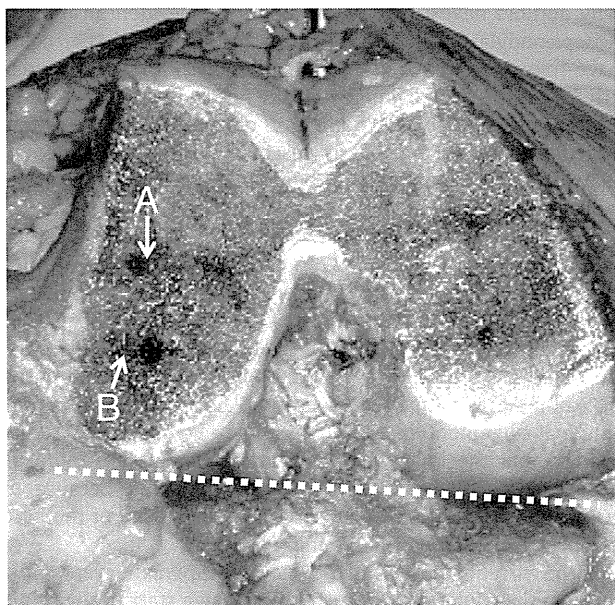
Axial cross-section of the right distal femur. A: a blue line “p-CTA $+2^\circ$ ” externally rotated from PCA. B: a blue line “p-CTA -2° ” externally rotated from the PCA. PCA is the dotted line in this figure.
